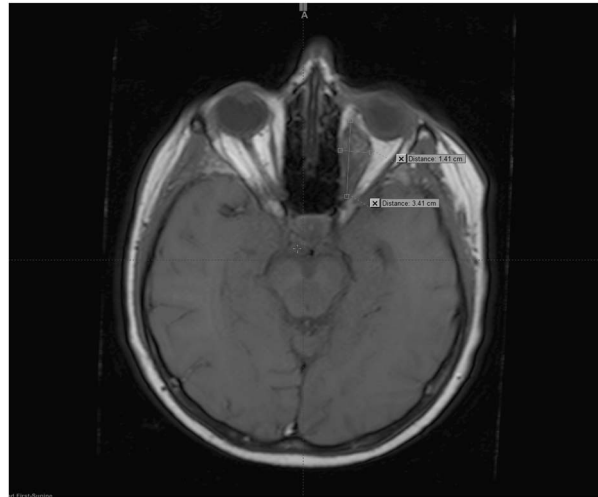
The magnetic resonance imaging of orbital metastasis 2 months after stereotactic radiotherapy.
